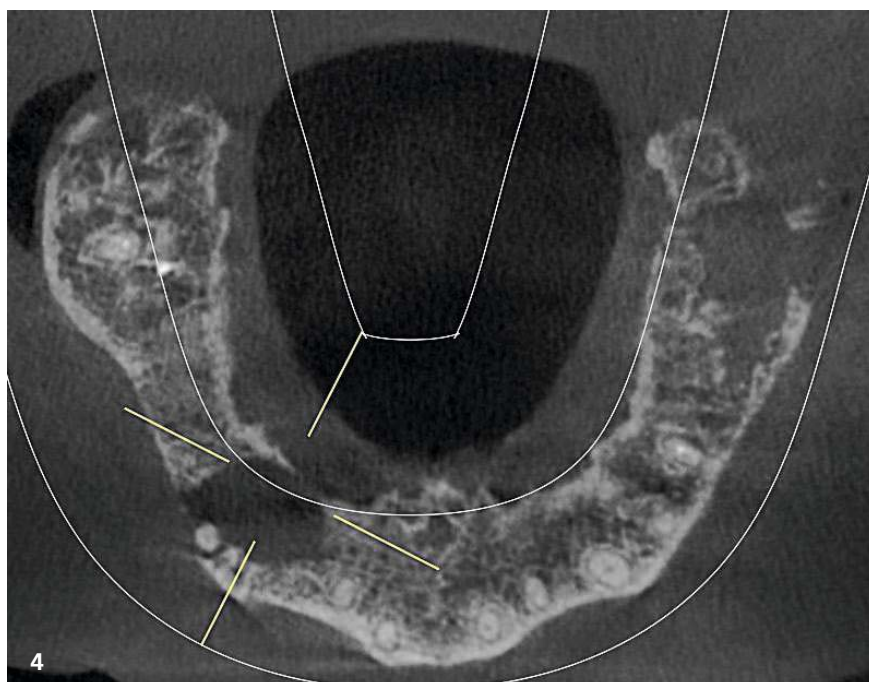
Diagnostic Radiographs: Radiovisiography (Vistascan, Dürr Dental) and CBCT (Orthophos SL, Dentsply Sirona).
